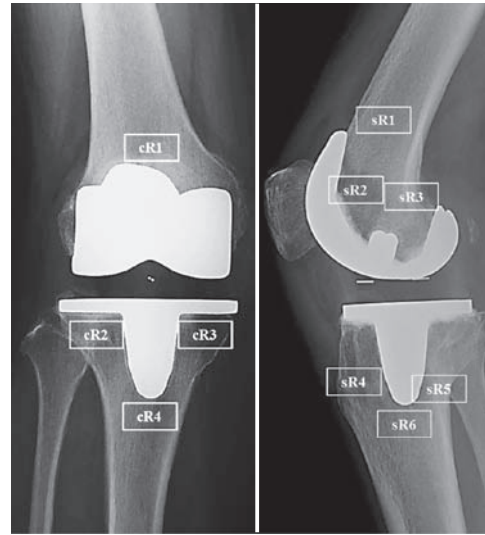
Radiograph showing the regions of interest (ROIs) used to measure bone mineral density by DXA in the coronal and sagittal views, preoperatively and at 1, 3, 6, 12, and 24 months postoperatively.
